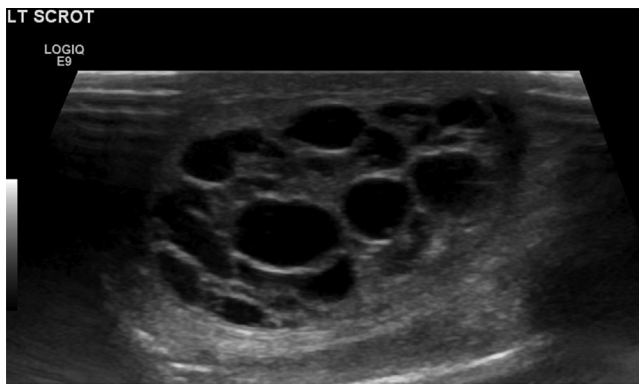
Sonogram of tumor showing complete cystic replacement of testes.
